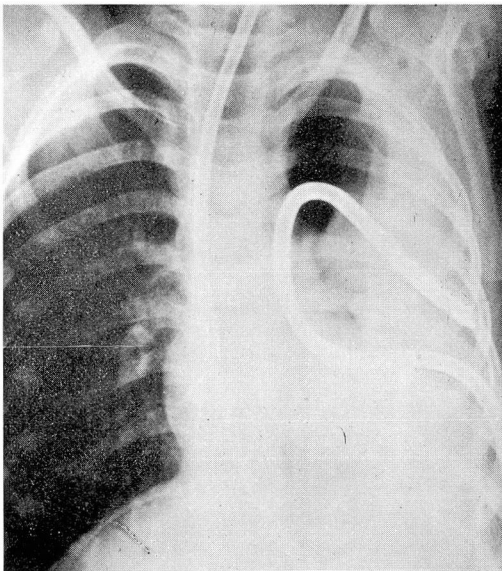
Roentgenogram showing that an anterior thoracotomy tube has partially reexpanded the left lung.
